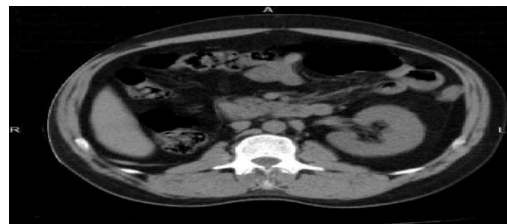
Plain CT axial image of a study patient showing absent right kidney – rightrenal agenesis.
